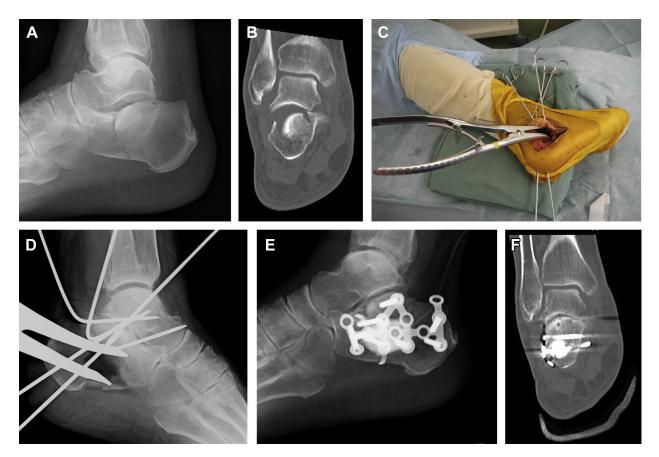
(*A*) Radiograph of the left calcaneus on the day of injury. (*B*) Computed tomography scan of the left calcaneus on the day of injury. A 76-year-old female had sustained an injury to her left calcaneus. The fracture type was graded as Sanders 2c and a joint depression fracture using the Essex-Lopresti classification (Böhler's angle -1° , Preiss' angle 19°, step off 6 mm, gap 3 mm). (*C*) Intraoperative photograph showing the reduction of the articular fragments temporarily held with a bone spreader. (*D*) Intraoperative radiograph showing Böhler's angle reduced anatomically. (*E*) Radiograph of the left calcaneus after surgery. (*F*) Computed tomography scan of the left calcaneus after surgery. The fracture was reduced and fixed anatomically (Böhler's angle 33°, Preiss' angle 15.7°, step off 0 mm, gap 1.3 mm).
